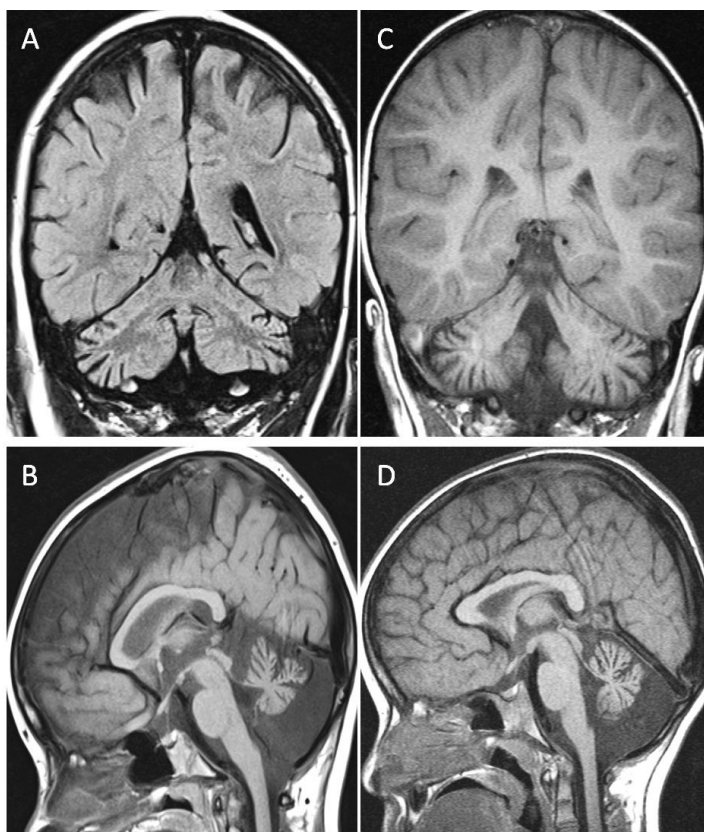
16: MRI brain scan findings in S20 and S21.
